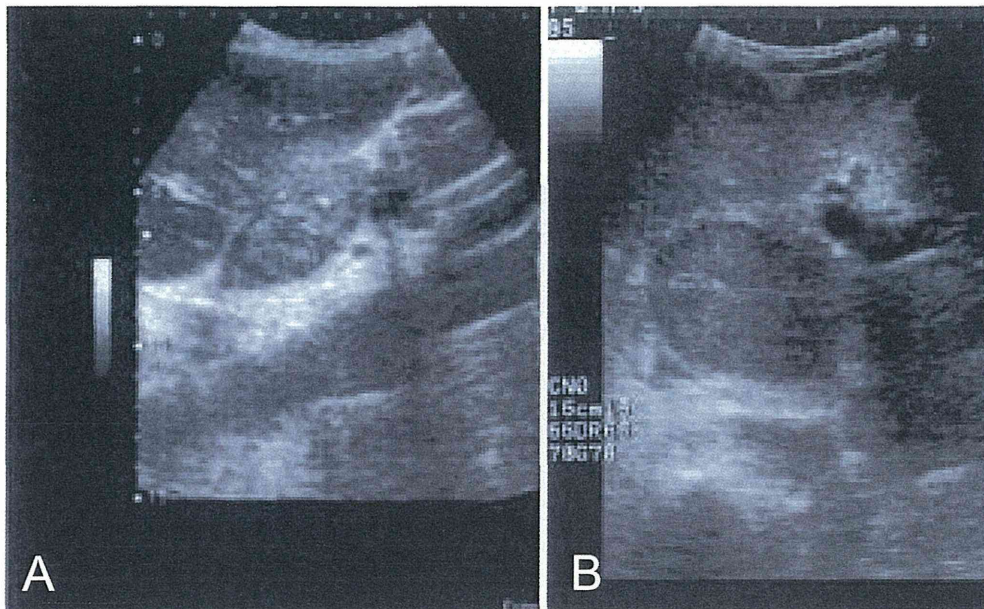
Ultrasound findings of the hepatic nodule in the caudate lobe
